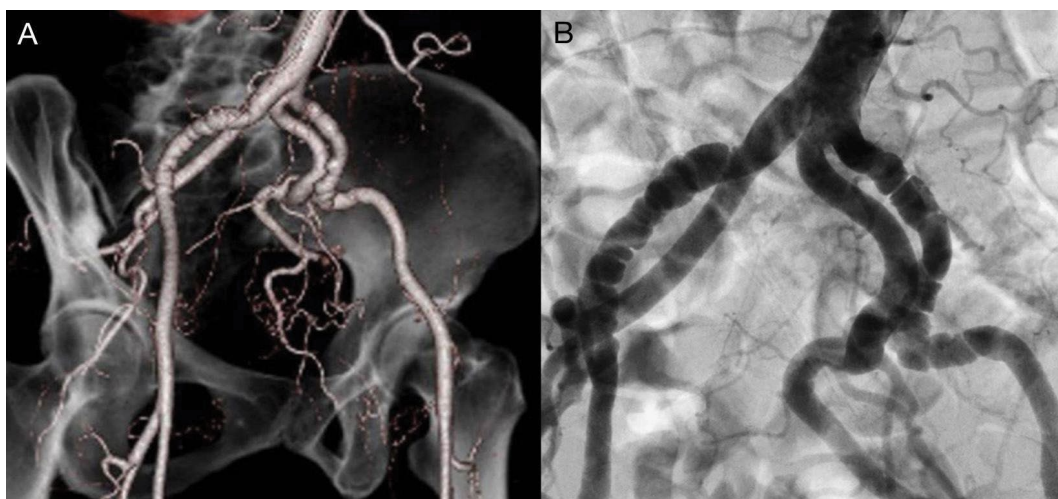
A) Three-dimensional computed tomography angiogram (CTA) of bilateral external iliac arteries showing a typical string of beads pattern [15]; B) Digital subtraction angiography (DSA) of external iliac arteries also shows the string of beads pattern on both sides [15].
